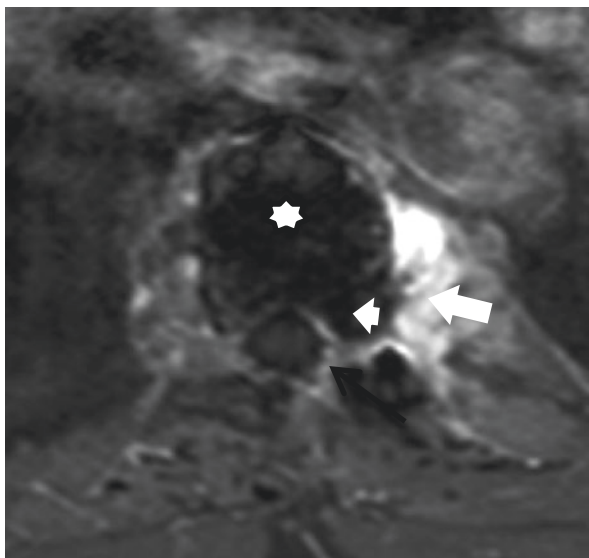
MR follow-up performed 2 years after the VP + percutaneous embolization with Onyx, fast spin-echo T1 MR image with fat suppression with contrast: complete filling of the intraosseous component of the hemangioma (*asterisk*), marked reduction in epidural component (*black arrow*) caused by glue (*head white arrow*), and persistence of the left paravertebral extraosseous component (*white arrow*), unchanged
